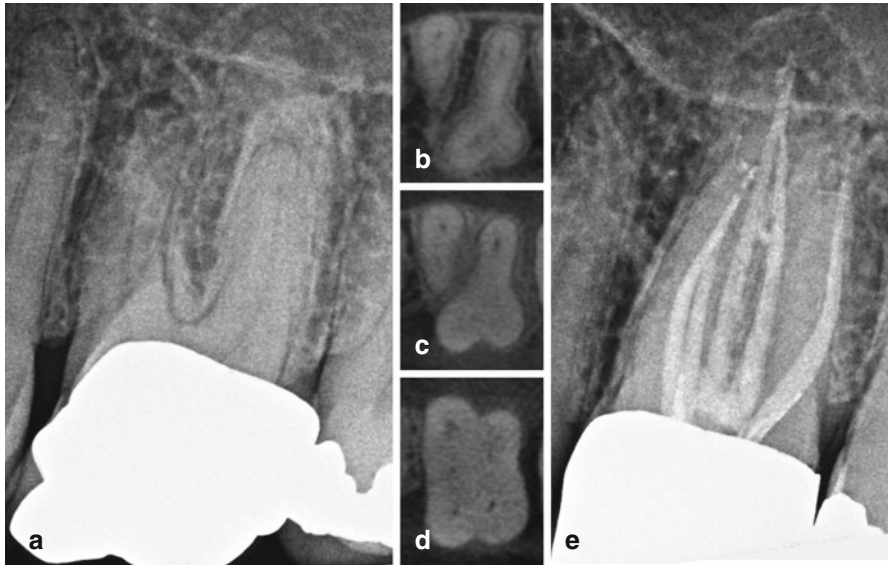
Preoperative periapical radiograph of a maxillary left first molar (a) with corresponding axial CBCT slices captured from the apical third (b), mid-root (c), and coronal third (d) demonstrating five separate root canal systems (two canals in the mesiobuccal root and two canals in the palatal root). The post-endodontic periapical radiograph demonstrates all identified root canal systems treated (e)
